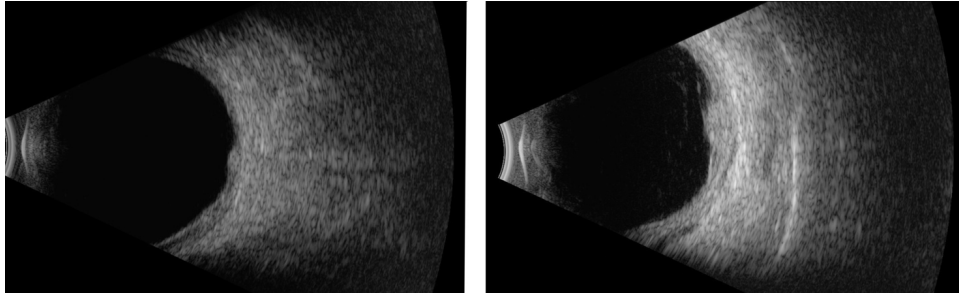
High-frequency B-scan ultrasonography (10 MHz) showing choroidal nevi-like lesions and diffuse choroidal thickening.
